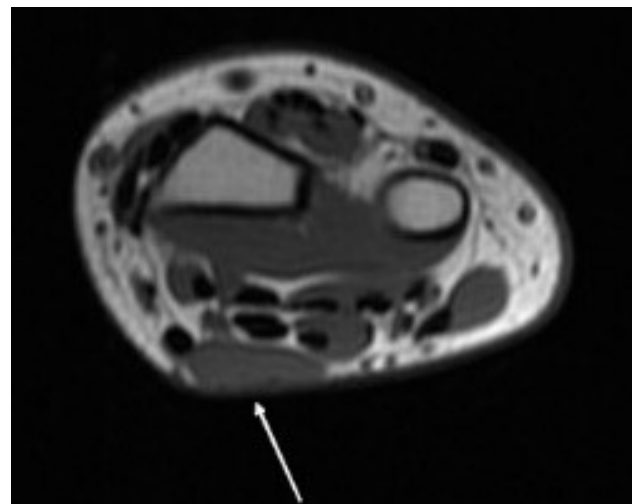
Axial T1-weighted image at the level of flexor tendons shows reverse palmaris longus muscle belly isointense to the adjacent muscles (white arrow).
